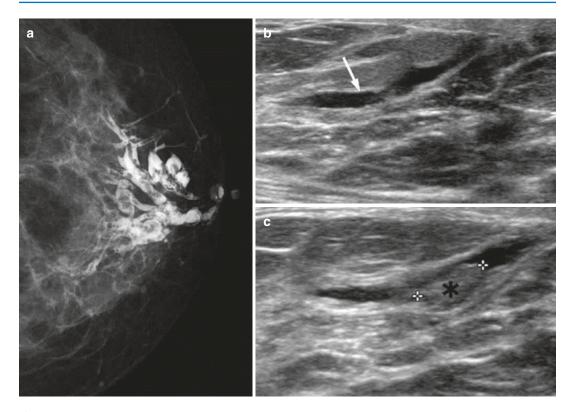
Mammary duct dilatation in a 49-year-old woman. (a) Left craniocaudal galactogram showing multifocal filling defects in the dilated ducts. (b, c) Sonograms
